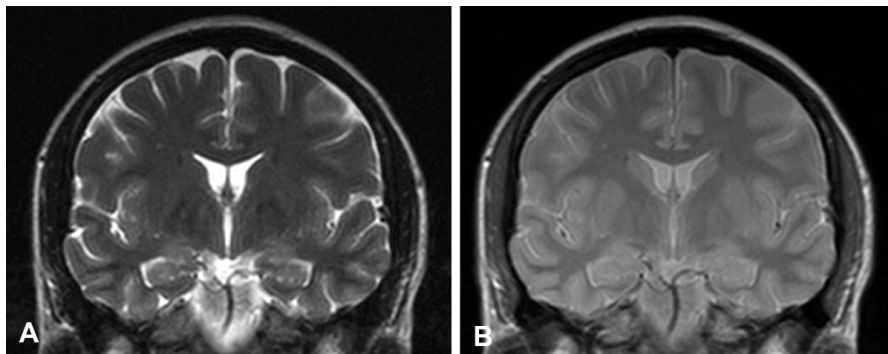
Initial brain magnetic resonance images (section Coronal 2) used for segmentation: A – T2-weighted image, B – PD-weighted image.
